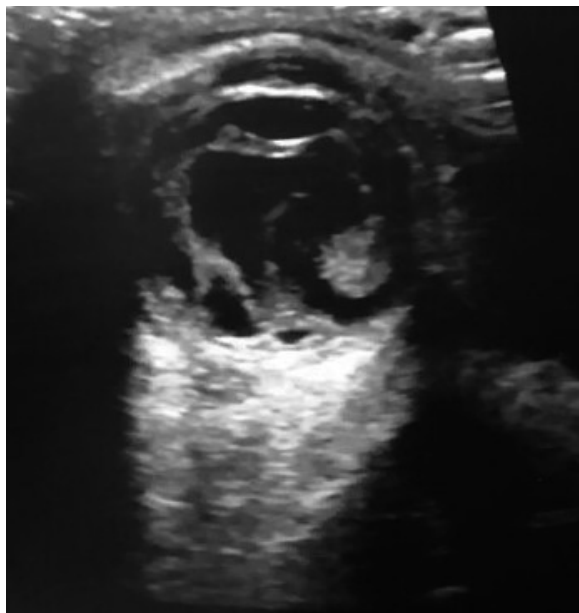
Ocular ultrasound of the right eye, showing a vitreous abscess with membrane formation, a choroidal thickening and an intact retina
